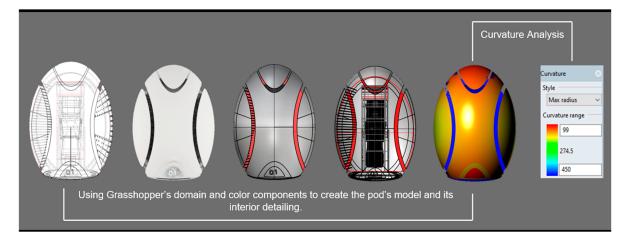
The "Reviving Pod" modeling design with technical, rendered, shaded, and X-ray view curvature analysis rendered in the Rhino program (computational modeling by the authors).
